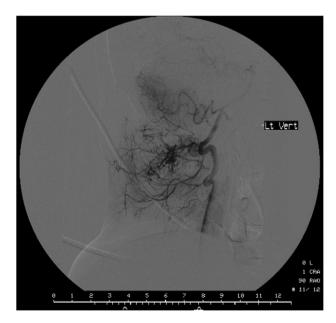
Computed tomographic angiography of the left vertebral artery showing the tumour deriving its vascular supply from the cervical and muscular branches of the artery.
